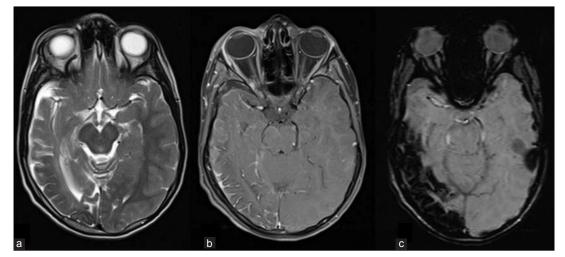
(a). T2 Weighted magnetic resonance image (MRI) showing right hemispheric atrophy with temporo-occipital cortical hypointensity, prominent sulcal spaces. (b). Gadolinium enhanced T1 weighted image showing right temporo-occipital sulcal enhancement consistent with pial angiomatosis. (c). Susceptibility weighted image (SWI) showing intense blooming of temporo-occipital cortex
